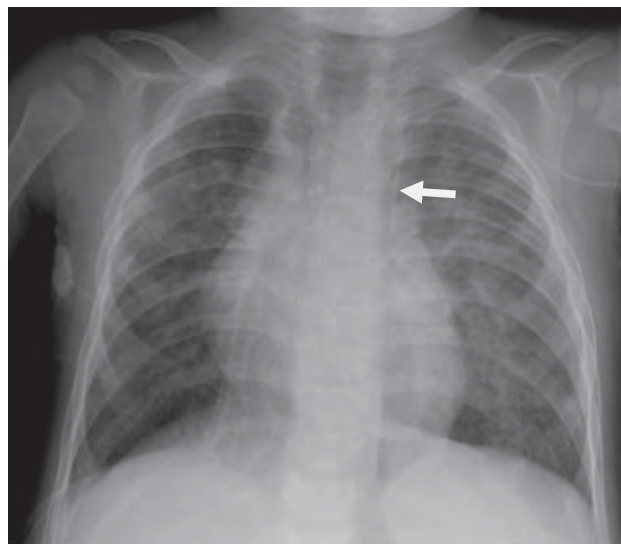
Frontal radiograph of the chest showing a left upper extremity PICC line descending along the left mediastinum in a left superior vena cava (arrow).
